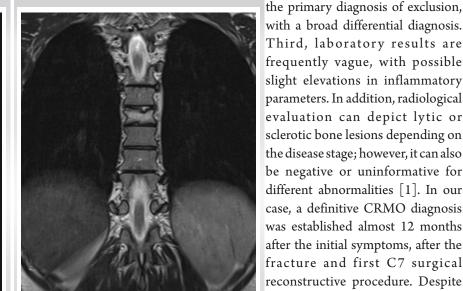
Magnetic resonance imaging of the thoracic spine. Coronal T2-weighted sequence (Fig. 3D) show partial depression of upper end plate of the seventh thoracic vertebra, accompanied with bone edema of the vertebral body.
